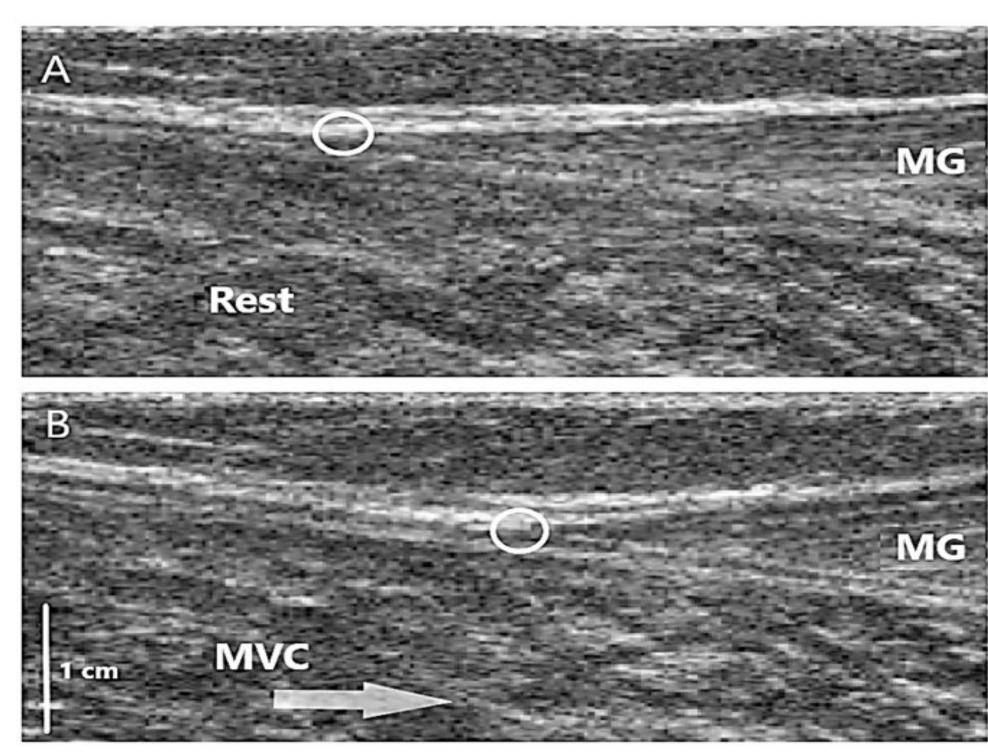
B-mode ultrasound images of the MG muscletendon junction (A) at rest and (B) during MVC. Circles indicate the position of the tracked muscle-tendon junction.
